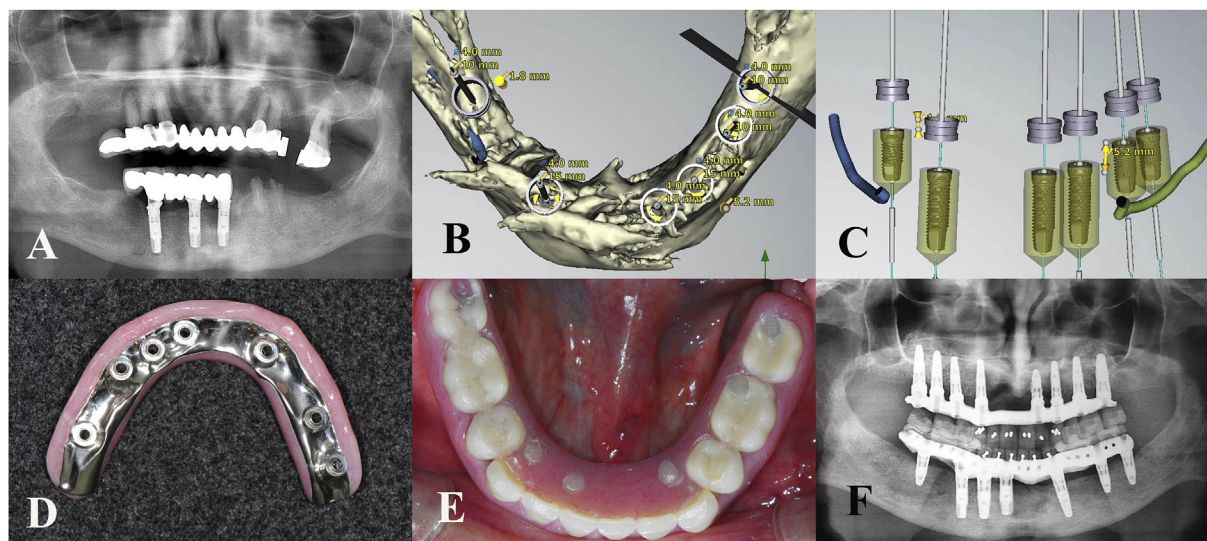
Clinical and radiographic photographs of the patient. (A) Panoramic radiograph of the patient before treatment. (B and C) Occlusal (B) and frontal views (C) of implants and inferior alveolar nerves during virtual implant placement. (D and E) Tissue-surface (D) and occlusal views (E) of the mandibular implant-supported fixed prosthesis. (F) Panoramic radiograph of the patient a year after implant placement.
